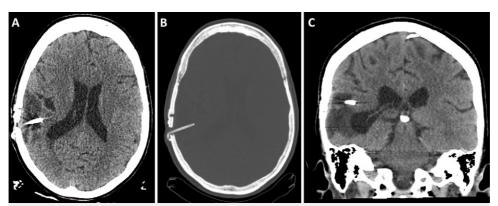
Axial computed tomography (CT) (A), axial bone window (B), and coronal (C) postoperative CT imaging without contrast demonstrating a right-angle shunt, resolution of the MLS and arachnoid cyst, with residual encephalomalacia.
